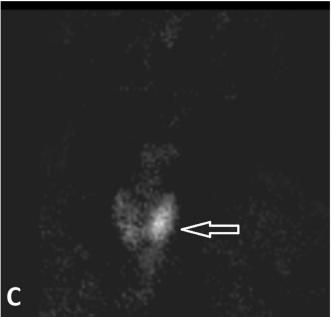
(A and B) A hypoechoic nodule on the lower pole of left thyroid lobe (arrows), (C) A scintigram with Tc-99m increasing radioactivity in the corresponding position (arrow).
